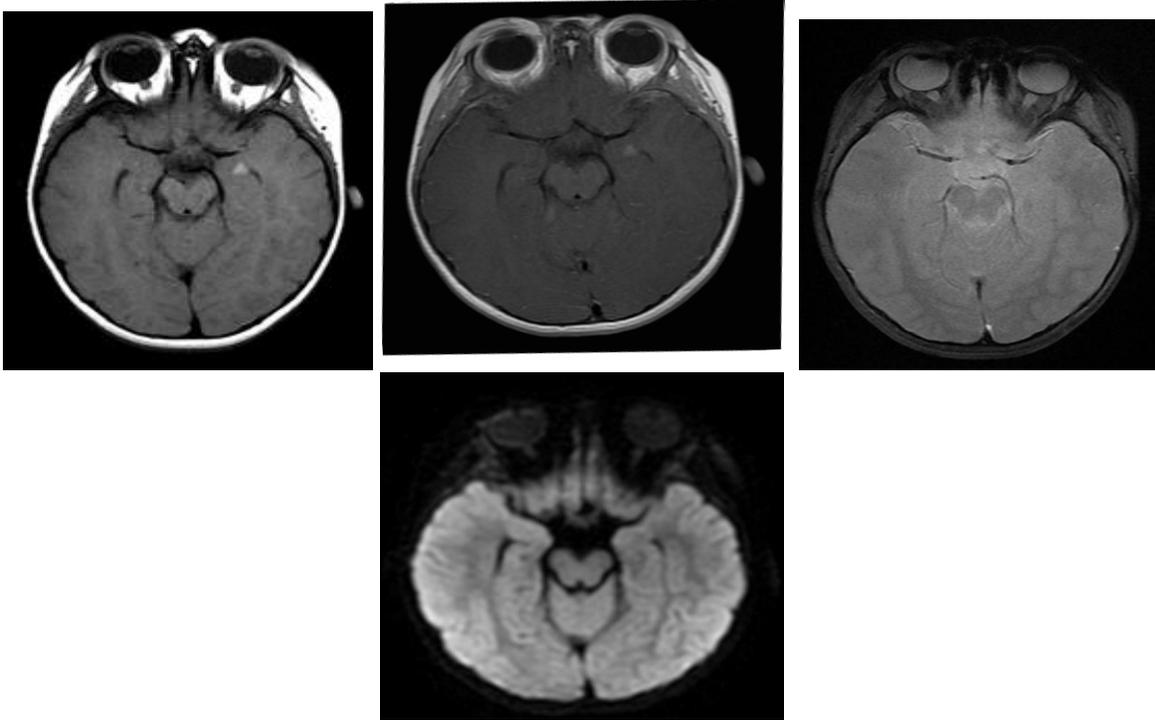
MRI axial sections. A, T1-weighted with evidence of a small area with high signal (arrow) located in the left mesial temporal lobe (tonsilla). B, T1 with paramagnetic contrast, no enhancement. C, T2 GRE; and D, DWI unchanged. Child, female, 1 year and 7 months old with Giant Congenital Neurocutaneous Melanosis.
